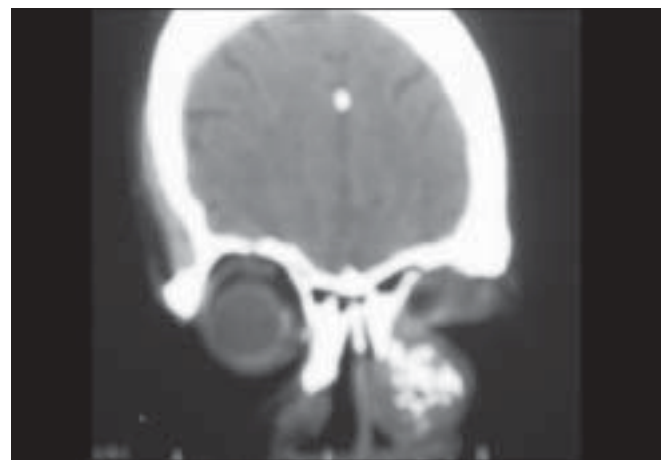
CT imaging of the maxillofacial region shows a heterogeneous mass over the left side of the nasal dorsum and frontal process of the left maxilla
